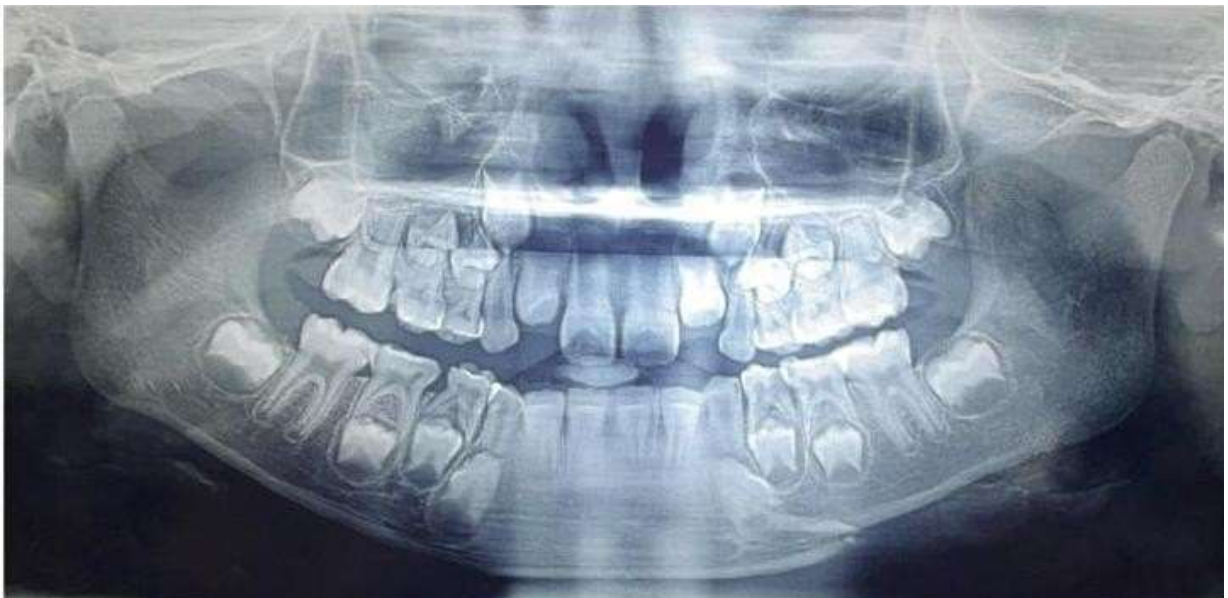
pre-Operative radiograph showing left mandibular body fracture with right condylar fracture.
